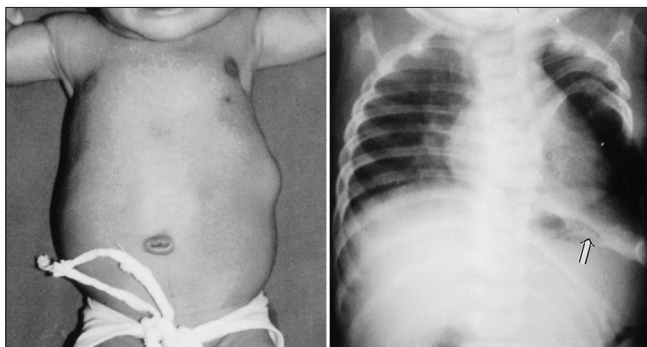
Clinical picture of patient A when he was a neonate, showing left-sided chest defect and chest radiograph showing rib defect
